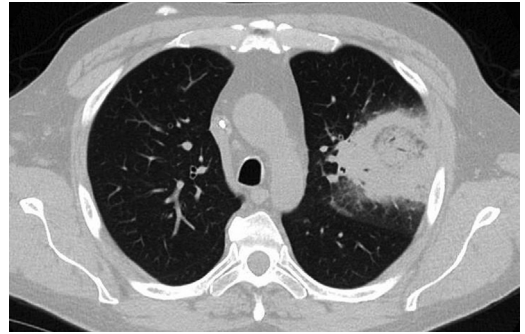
CT from a febrile neutropenic patient demonstrates focal subpleural consolidation with central ground glass (reversed halo sign) shown to be caused by Mucormycosis by BAL PCR. A single subpleural lesion is a common imaging appearance for this disease.
